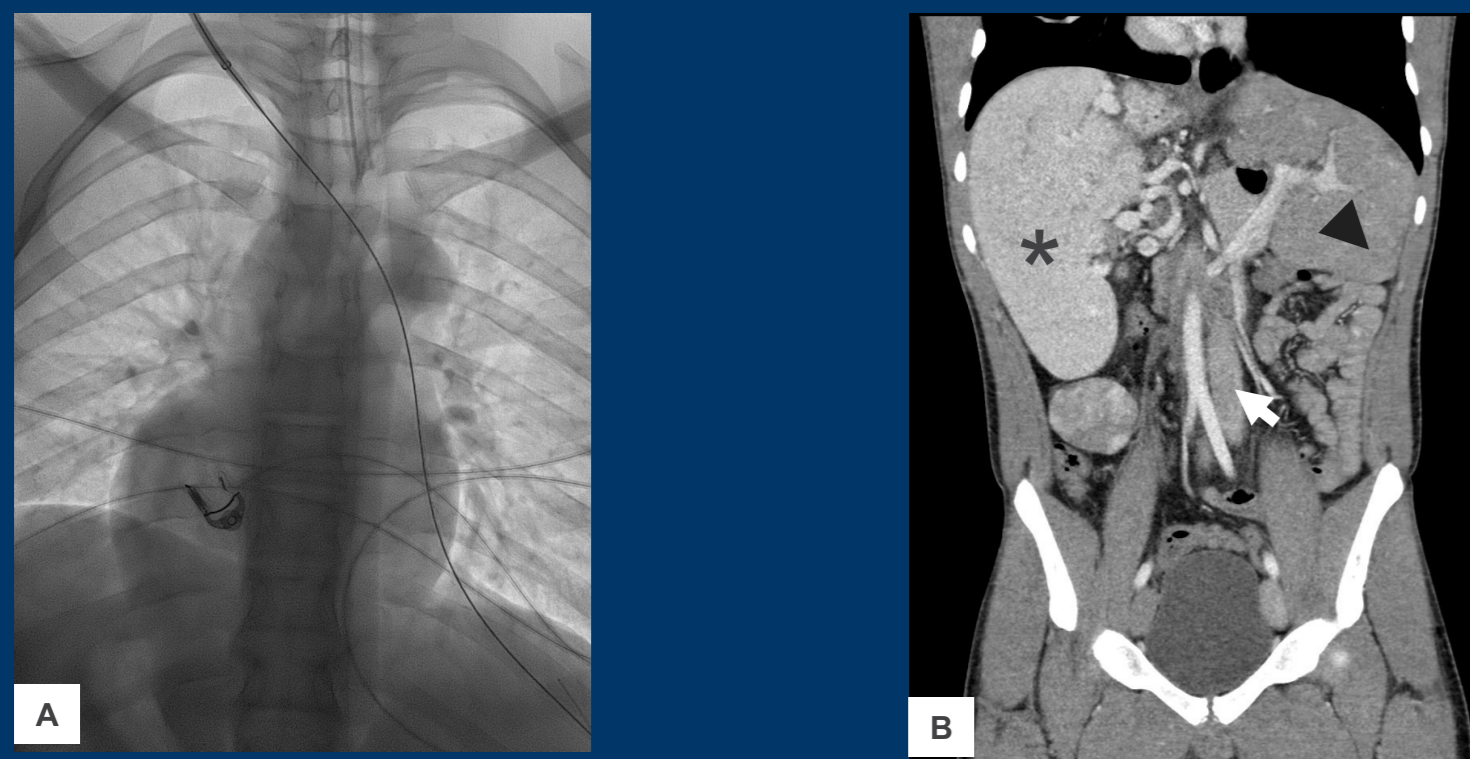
Chest spot fluoroscopic image (A) and coronal CT reformat (B) showing the patient's variant situs inversus anatomy. Note the left-sided IVC (arrow), right-sided spleen (\*) and left-sided cirrhotic liver (arrowhead).
